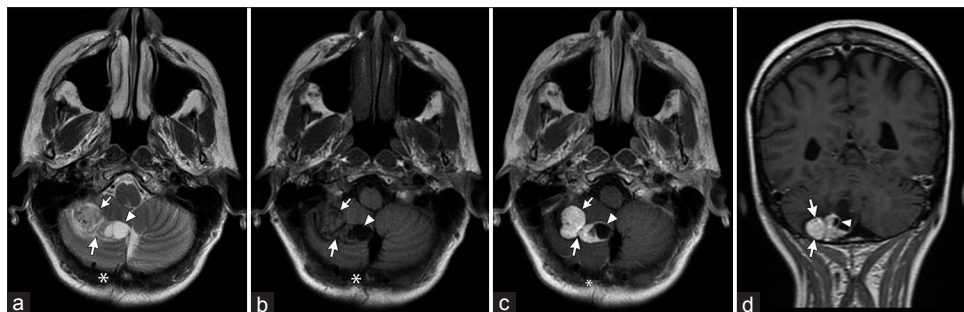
Preoperative brain MRI sequences. (a) T2-weighted axial; (b) T1-weighted axial without contrast; (c) T1-weighted axial with contrast; (d) T1-weighted coronal with contrast. Images show a bilobular well-defined homogeneous solid mass (arrows) with a medial cystic component (arrowheads) involving the inferior and medial aspects of the right cerebellar hemisphere, consistent with recurrent disease. Adjacent postsurgical changes (asterisks) are also observed
